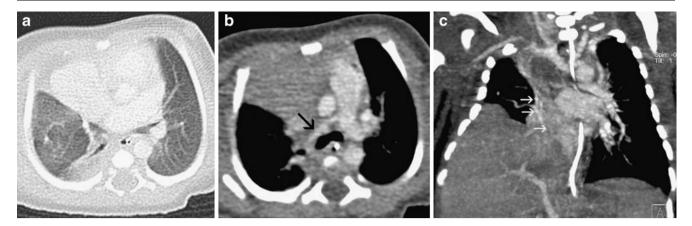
Multidetector CT. a Axial section with lung window through the chest shows a small right lung with ground glass densities. b Axial section (arterial phase following contrast medium injection) shows a
